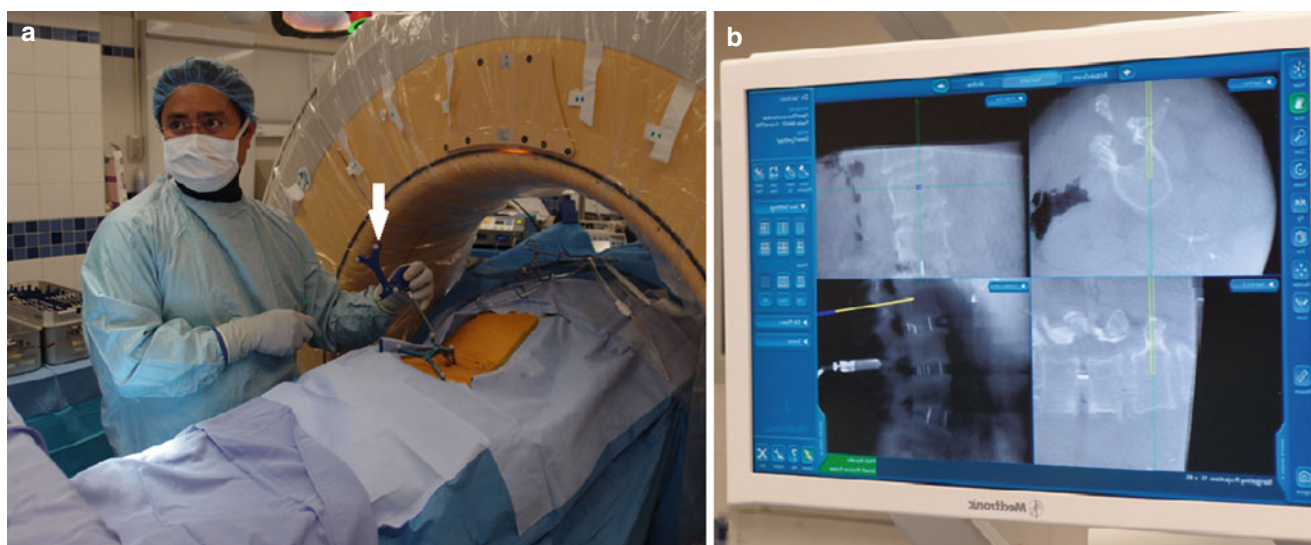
Operative setup where the new generation intraoperative CT scanner gantry is “parked” at the head of the spinal table. To ensure clarity and accuracy of image, tracking spheres (*arrow*) must
